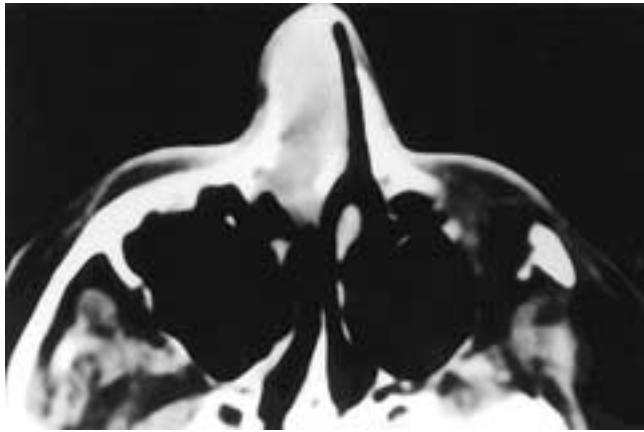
Axial CT scan shows a soft-tissue mass in the right nose and anterior nasal fossa. There is widening of the involved right side, and there is no bone erosion. This patient had a large cell lymphoma.
